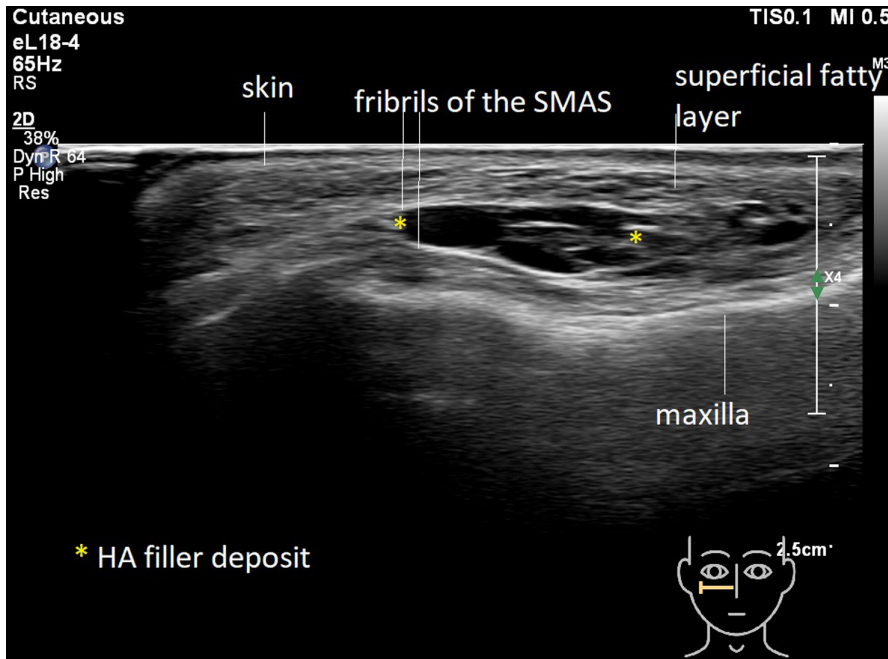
Ultrasound imaging showing the hyaluronic acid-based filler material in close topographical relationship to the superficial musculoaponeurotic system (SMAS) between the superficial and the deep fatty layer.
